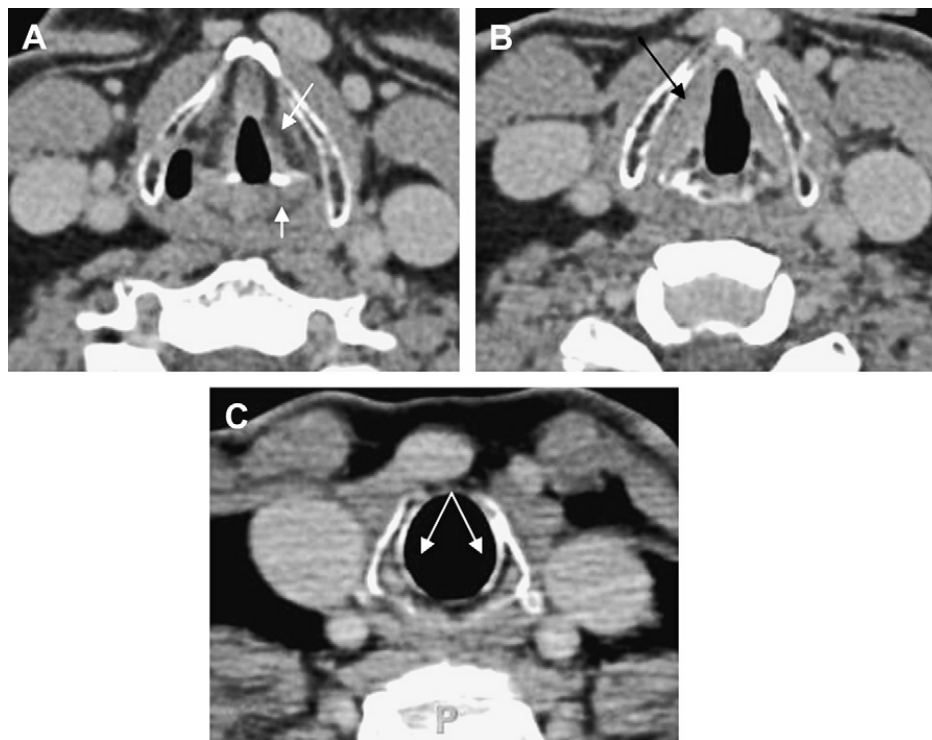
Axial CT images from the supraglottic (A), glottic (B), and subglottic
